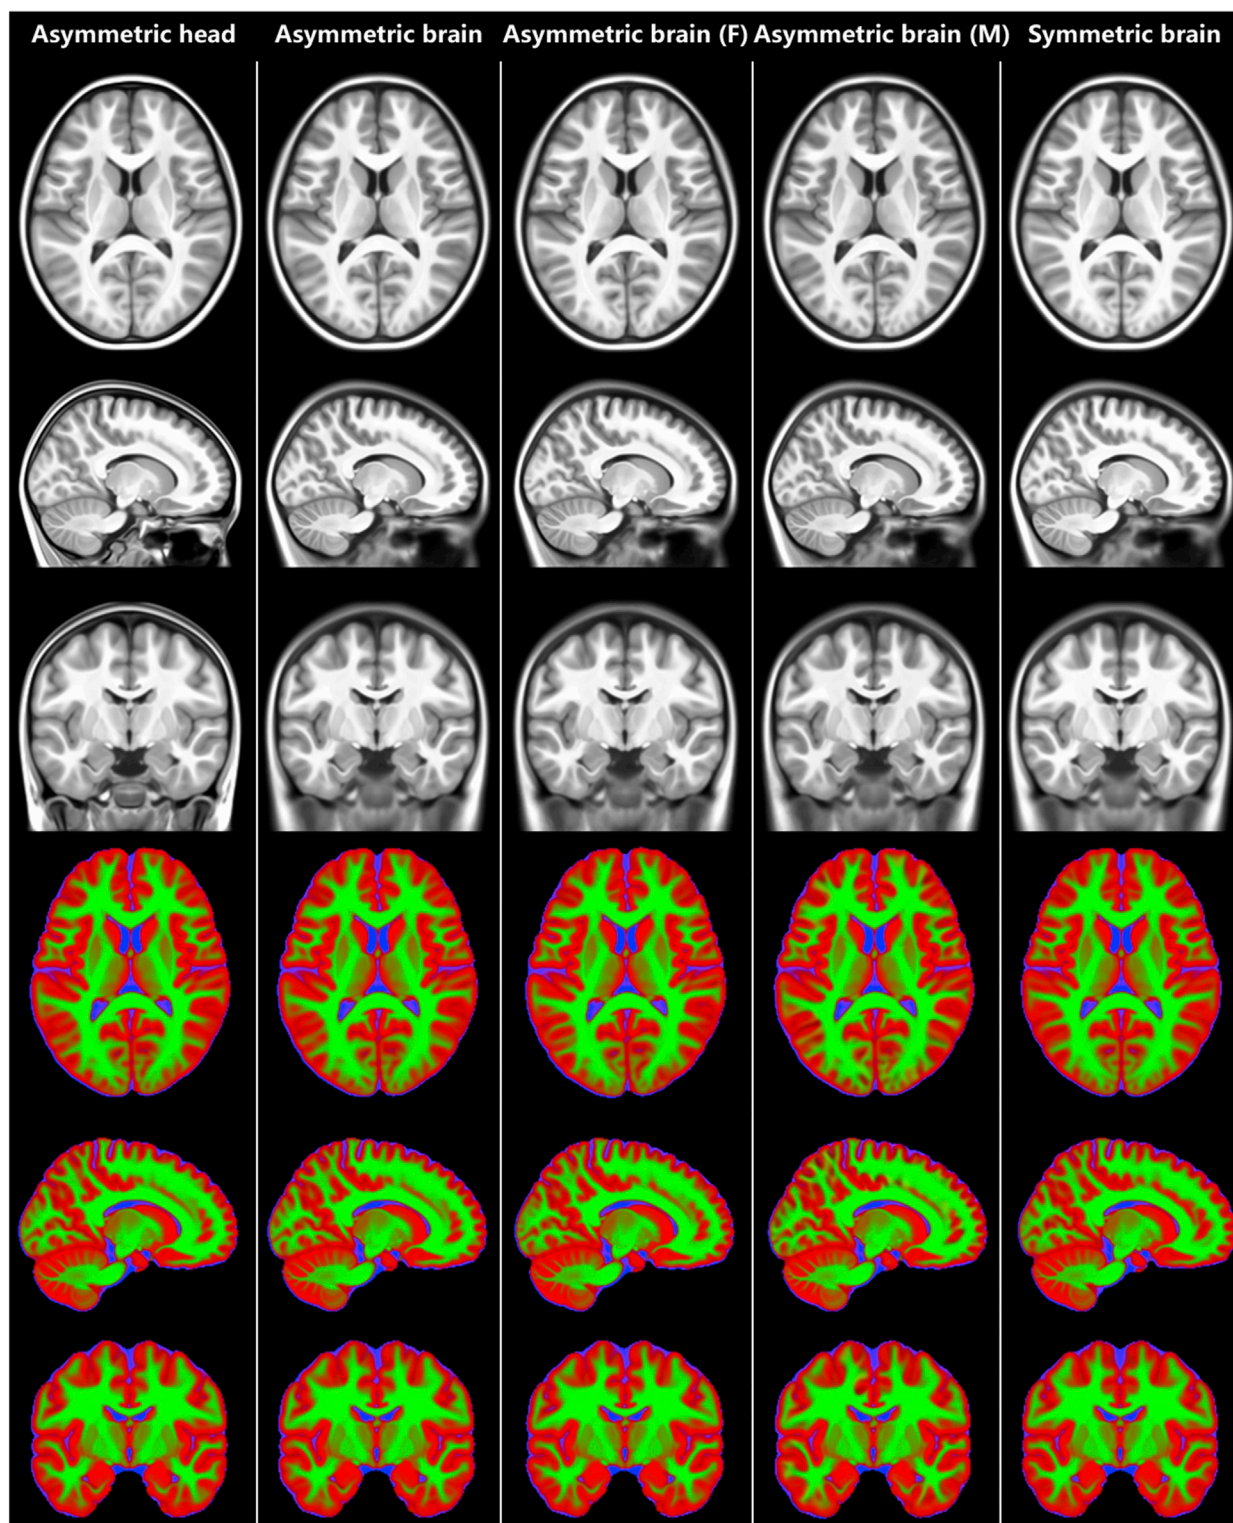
Detailed slices of the Chinese pediatric atlases at a full age range (6–12 years old). The T1-weighted templates are shown in the upper panel and the tissue probability atlases are shown in the lower panel. These templates include the asymmetric head/brain templates, asymmetric sex-specific brain templates (F, female; M, male) and the symmetric brain template. GM, gray matter; WM, white matter; CSF, cerebrospinal fluid. The templates are displayed in the neurological convention.
